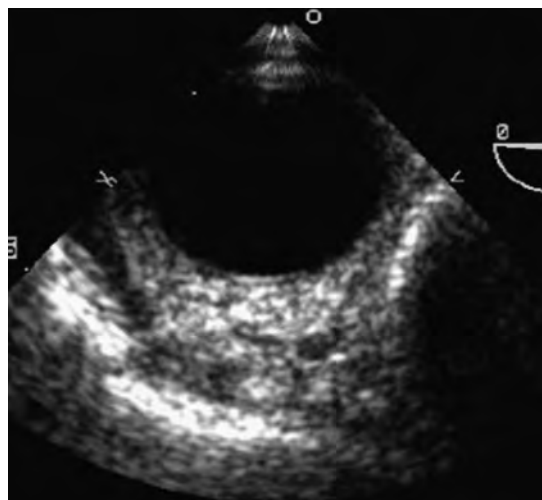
Upper esophageal transesophageal echocardiographic short-axis view of the distal ascending aorta (at zero degree of rotation). No intimal flap is compatible with dissection. However, there is extensive anterior intramural hematoma.
